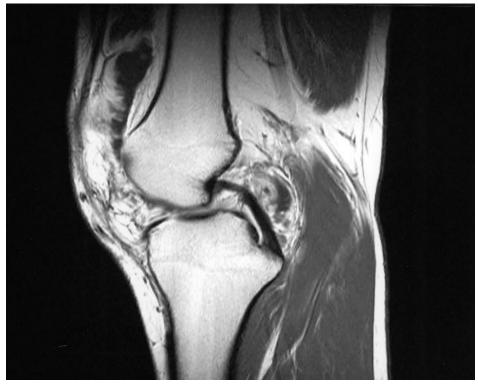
Contrast enhanced T1 weighted sagittal MRI scan without fat suppression reveals diffuse enhancing synovial thickening and fluid collection.
